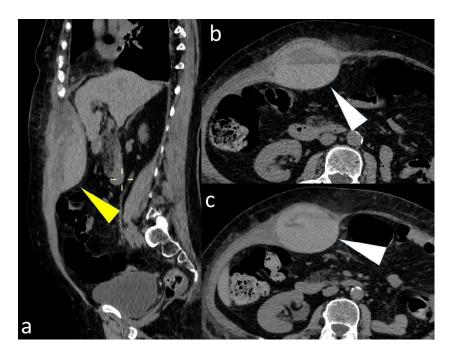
Unenhanced computed tomography (CT) at the level of the upper right abdomen (A) shows, in sagittal plane, a large rectus sheath hematoma (yellow arrowhead) with hematocrit effect (white arrowhead in axial images B and C).
